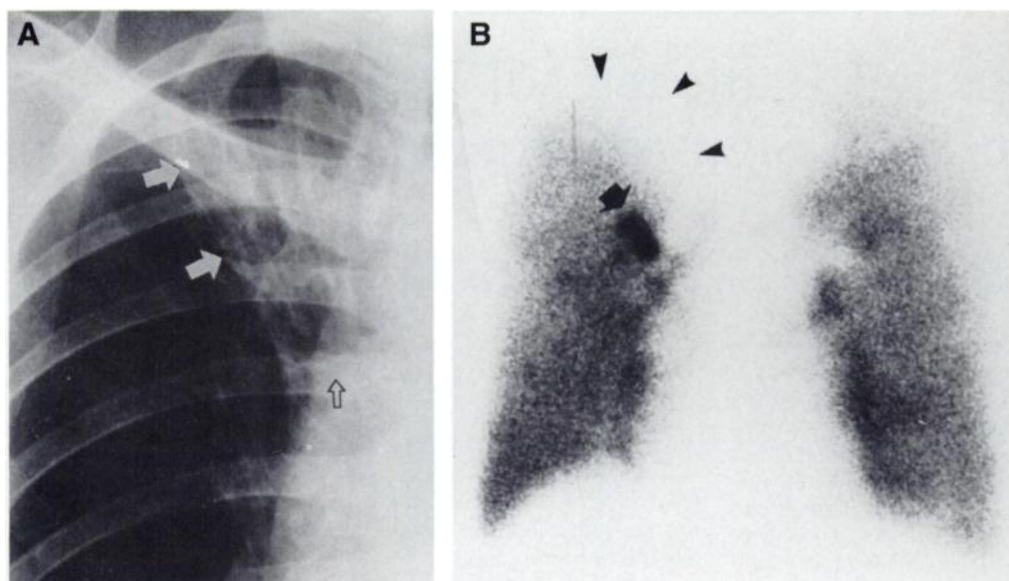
Typical, prestenotic aerosol deposition in a 57-yr-old man with a right upper lobe bronchus obstruction due to tuberculosis. (A) Posteroanterior right upper chest radiograph shows increased density with crowded vascular markings of collapsed lung (arrows) and cranially shifted hilum (open arrow). Obstruction is not depicted. (B) Anterior aerosol scan reveals intense tracer deposition in the clubbed, dilated, prestenotic, right upper lobe bronchus (arrow). Also, note a large deposition defect in the collapsed, right upper lobe (arrowheads).
